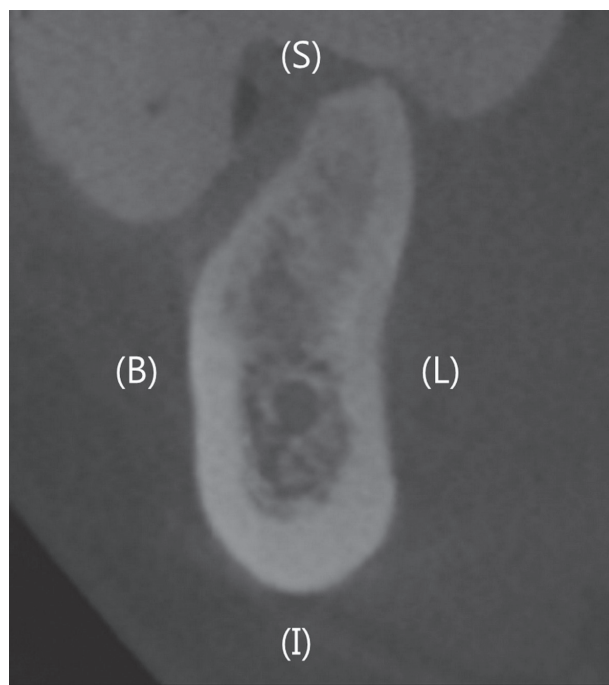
Buccolingual section of edentulous ridge. Buccolingual section of edentulous ridge taken from computed tomography scan. (B): buccal, (L): lingual, (S): superior, (I): inferior.
